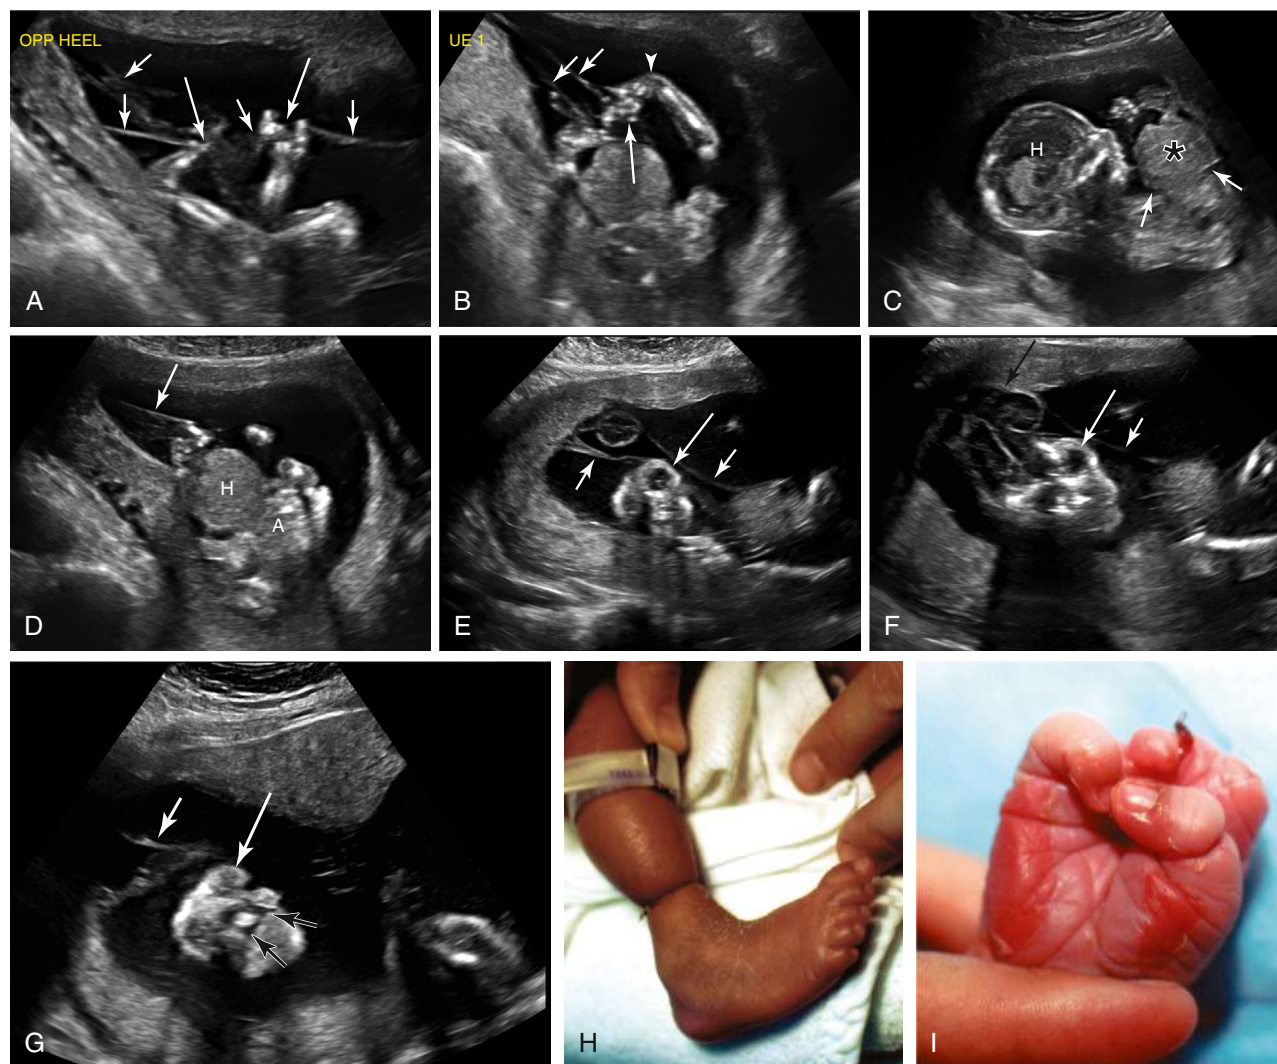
Amniotic band sequence in two different fetuses. A and B, Effects on the extremities. Limbs of a fetus with amniotic band sequence show multiple amniotic bands (short arrows, A and B), amputation of fingers and toes (long arrows, A and B), and a fixed deformity of the hand at the wrist (arrowhead, B). C and D, Effects on the thorax and abdomen of the same fetus as in A and B. Sagittal image (C) shows a thoracoabdominal wall defect (arrows) with a large amount of herniated abdominal and thoracic contents (asterisk) outside the body. White H, Head. D, Axial image of the fetal abdomen (A) confirms the presence of a large ventral abdominal hernia (H), in the setting of amniotic bands (arrow). E to G, Effects on craniofacial structures in a different fetus. E, Coronal image of face shows multiple amniotic bands (short arrows) and nonvisualization of the calvarium. This results in a craniofacial appearance that resembles anencephaly (long arrow). F, A large encephalocele (black arrow) is seen above the level of the orbits (long white arrow) in a different scan plane. An amniotic band (short white arrow) is also seen. G, Coronal image of anterior portion of face shows facial clefts (black arrows) due to amniotic bands. Short white arrow, Amniotic band; long white arrow, orbits. H, Band constricting the ankle, leading to deformational defects. I, Pseudosyndactyly, amputation, and disruption of finger morphogenesis. (A–G from Hertzberg BS, Middleton WD. *Ultrasound: The Requisites*. 3rd ed. Philadelphia: Elsevier; 2016. Figs. 19–22; H and I from Jones KL, Smith DW, Hall BD, et al. *A pattern of craniofacial and limb defects secondary to aberrant tissue bands*. *J Pediatr*. 1974;84:90–95.)
